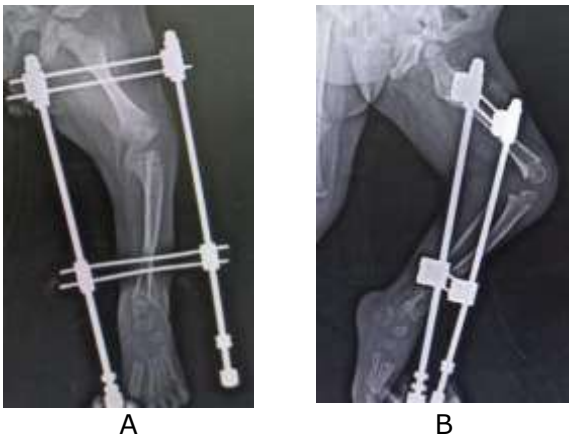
A & B – Post op x-ray
